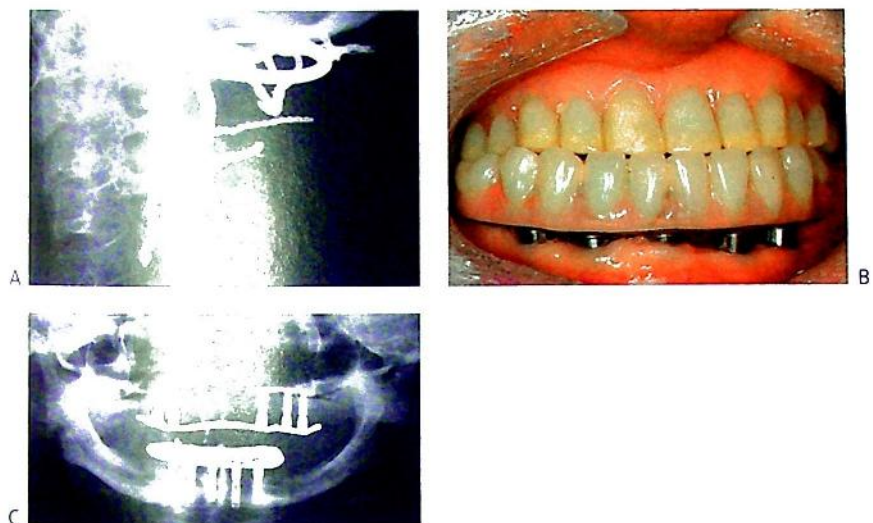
(A) The 'Ransford Loop' used to stabilize the vertebral column in a child with type IV osteogenesis imperfecta and basilar compression. This life-saving procedure is performed by an anterior approach through the pharynx, splitting the palate and sectioning the odontoid process of C2. The vertebral column is then wired to the occipital bone. This child initially presented with trigeminal neuralgia caused by pressure from C2 on the pons. (B) In spite of the bone pathology, osseointegrated implants can be successfully placed in patients with osteogenesis imperfecta. The same patient as in Figure 11.36A was rehabilitated with implant supported dentures following his surgery. (C) The panoramic radiograph shows the survival of the implants at 9-year follow-up.
